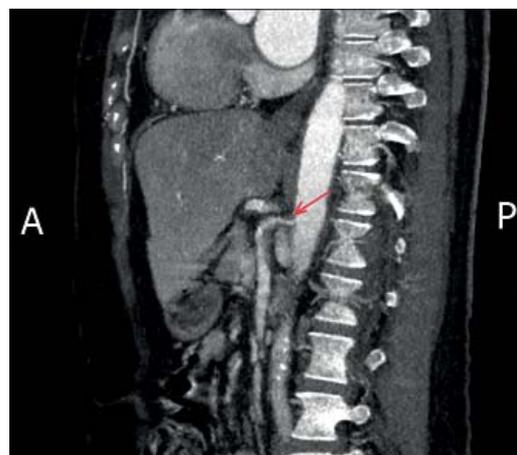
CT scan of the abdominal aorta (sagittal plane). Ostial stenosis of the superior mesenteric artery (red arrow)
